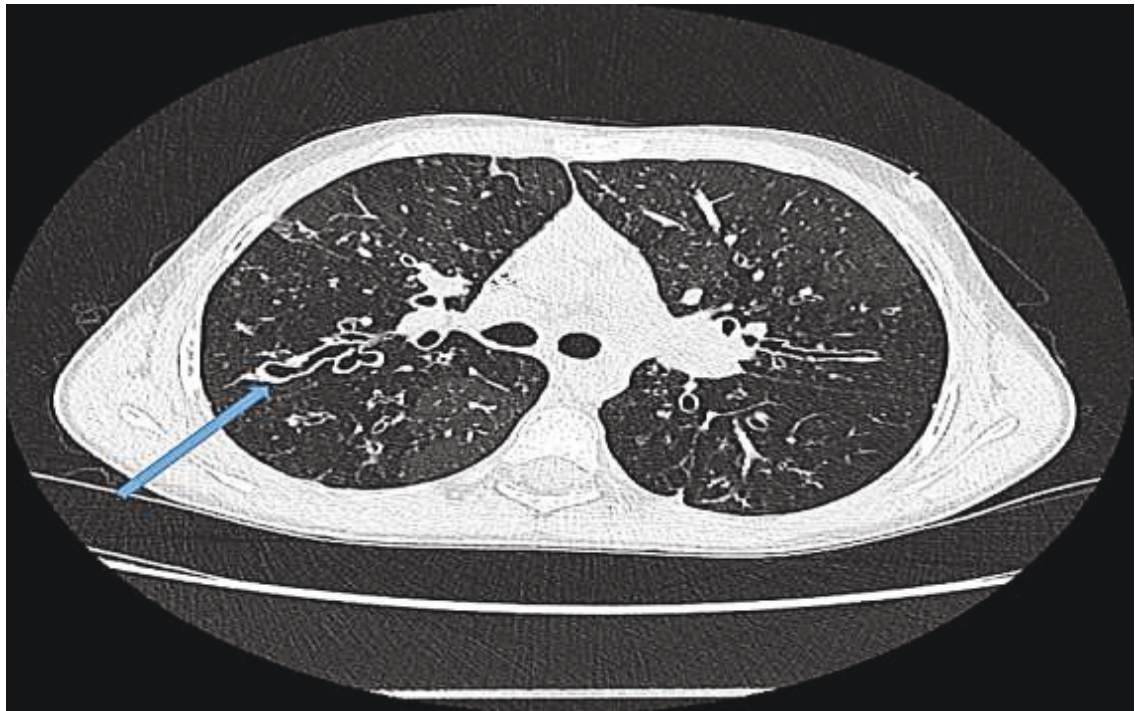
Computed Tomography of bronchiectasis
